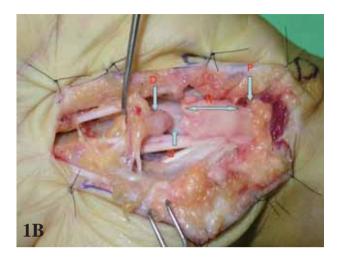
(1A). Ultrasonographic image depicting a transection (G) of the median nerve in the left palm. Proximal stump (P), distal nerve stump (D), neuroma (N). (1B). Intraoperative photography showing the complete nerve gap (G), distal (D) and proximal (P) nerve stumps and neuroma formation (N).
